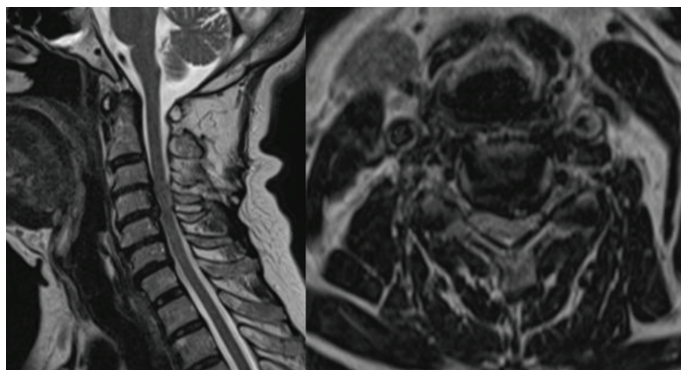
T2-weighted cervical spine MRI in sagittal (left) and axial (right) planes shows posterior disc herniation at C3–C4 and C4–C5 with significant spinal cord compression. There is evidence of severe canal stenosis and T2 hyperintense intramedullary signal suggestive of chronic myelopathy. The axial view reveals markedly reduced perimedullary CSF space, confirming spinal cord compression.
